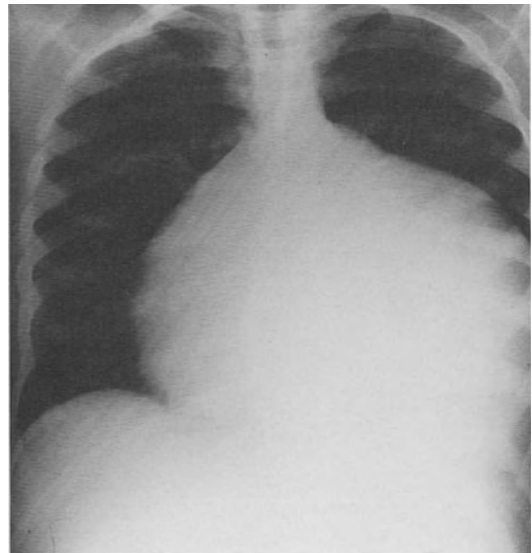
Chest X-ray in a case of severe Ebstein disease demonstrating massive cardiomegaly.
